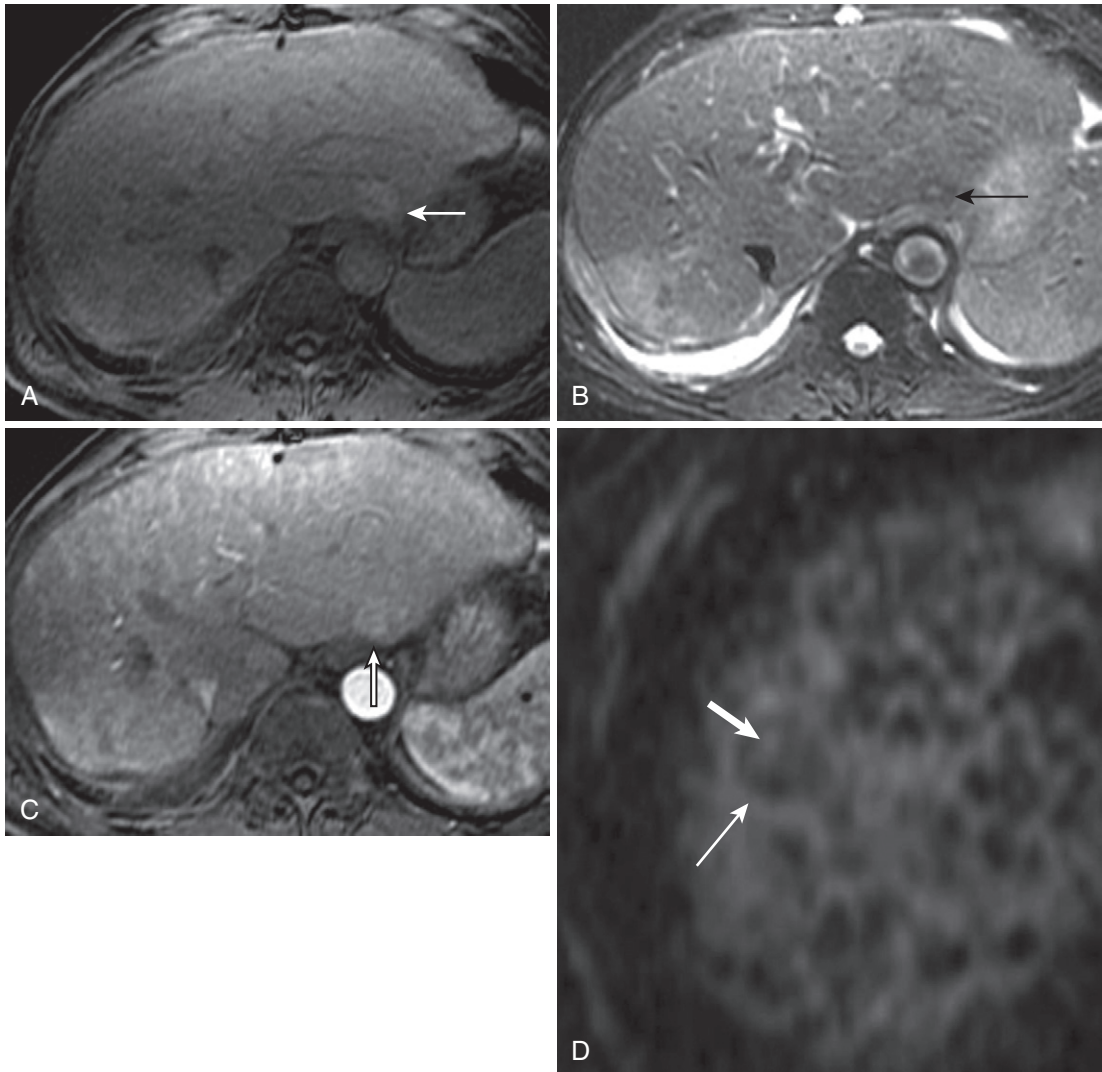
Nodule within a nodule. The axial fat-suppressed unenhanced T1-weighted image (A) reveals a hyperintense lesion (*arrow* in A) in the lateral segment of a cirrhotic liver characteristic of a dysplastic nodule, which is hypointense on the moderately T2-weighted image (*arrow* in B) with a punctate intralesional hyperintensity. C, The arterial phase image demonstrates corresponding ill-defined central enhancement (*arrow*) suspicious for HCC. D, A magnified axial moderately T2-weighted image in a different patient with severe cirrhosis reveals a dominant hypointense nodule (*thin arrow*) with intralesional hyperintensity (*thick arrow*) exemplifying the nodule-within-a-nodule appearance of early HCC.
